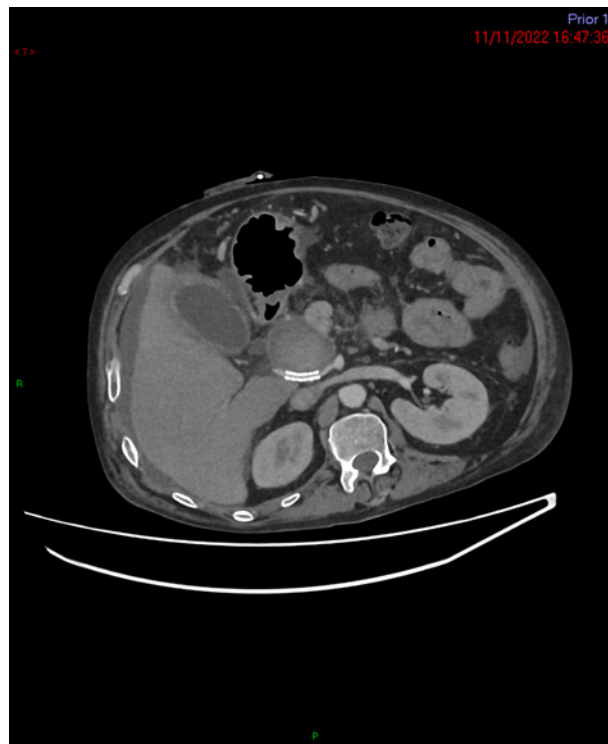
Contrast-enhanced CT abdomen 5 days following the exclusion of the pseudoaneurysm.
